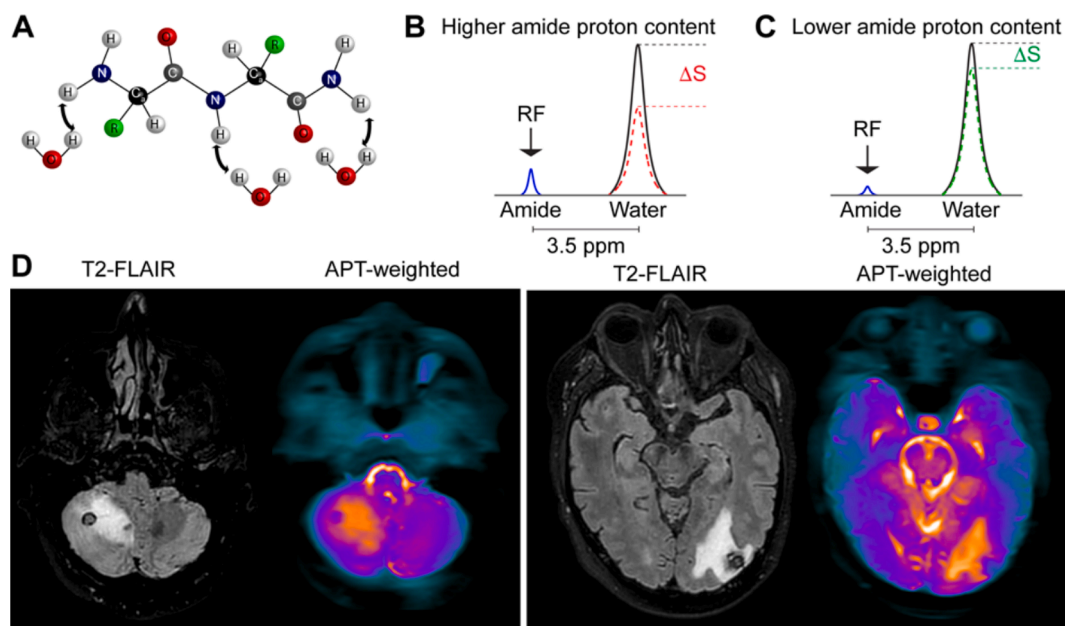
Chemical exchange saturation transfer (CEST) magnetic resonance imaging (MRI). Like other MRI contrasts, CEST MRI measures water signal, however, exploits the physical property that many proton moieties, such as amide protons on the peptide backbone as shown in (A), are in constant exchange with water. As different protons resonate (e.g., absorb radiofrequency, RF, energy) with discrete and unique energies, it is possible to apply RF energy at the resonance of the exchanging proton, and subsequently allow time for the proton to exchange with surrounding water protons. Amide protons resonate at approximately 3.5 parts per million (ppm) from the water resonance. The degree of attenuation in the water signal with vs. without the RF pre-pulse can be used to estimate the exchanging proton concentration (B-C), and, as effects are base-catalyzed over a physiological range, pH. (D) Example images obtained in our lab of a 61-year-old male with metastatic renal cell carcinoma and right cerebellar and left occipital lesions, each with a hemorrhagic core and surrounding edema. The amide proton transfer (APT)-weighted images, which are proportional to the protein content, show low protein content in the hemorrhagic core and high content in the surrounding edema and tumor margins [37].
